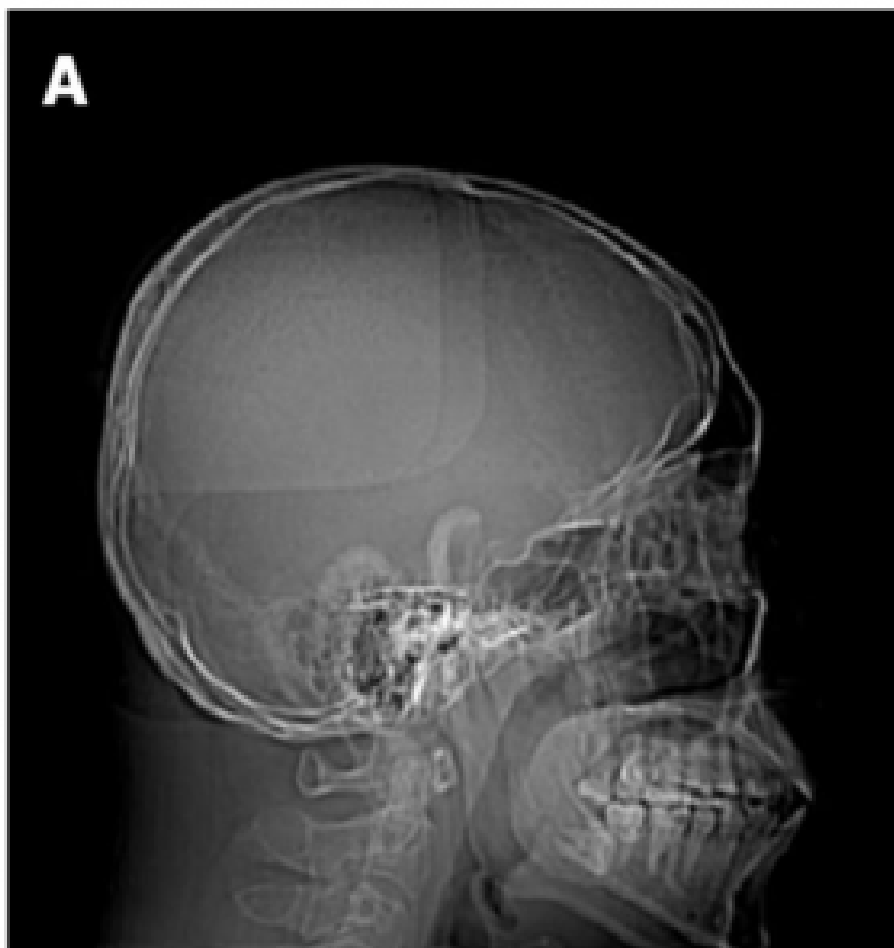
A. Head computed tomography (CT) scan.¹
